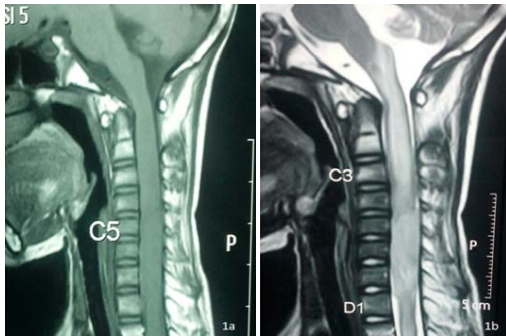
(a) T1 –MRI of cervical spine showing isointense lesion, (b) T2-MRI showing heterointense signal extending from C4-D1 with perilesional hyperintense signal
